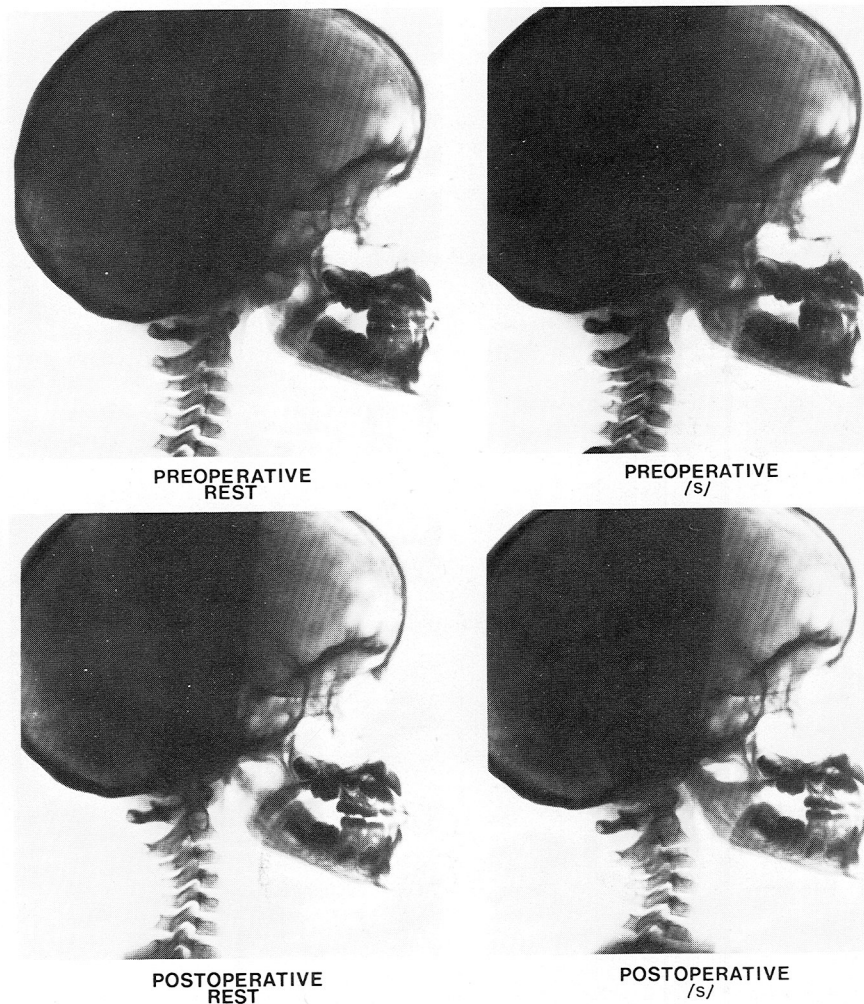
Two preoperative and two postoperative cephalometric radiographs of one subject during physiological rest and during sustained production of /s/.
